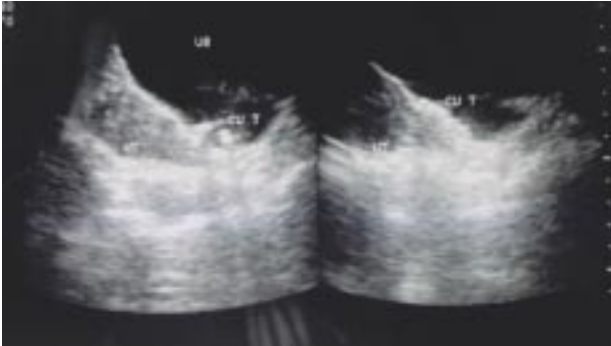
Ultrasound pelvis revealed an echogenic linear structure in the lumen of the urinary bladder in contact with the base of the bladder. UB – Urinary Bladder, UT – Uterus, Cu T – Copper T IUCD
